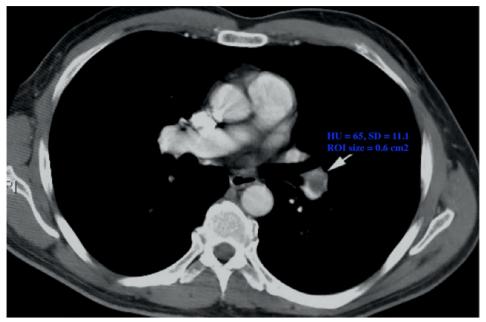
Hounsfield unit (HU) density measurement in computed tomography. Circular regions of interest (ROIs) were placed within the most homogeneous and centrally located part of the thrombus on axial computed tomography (CT) slices
